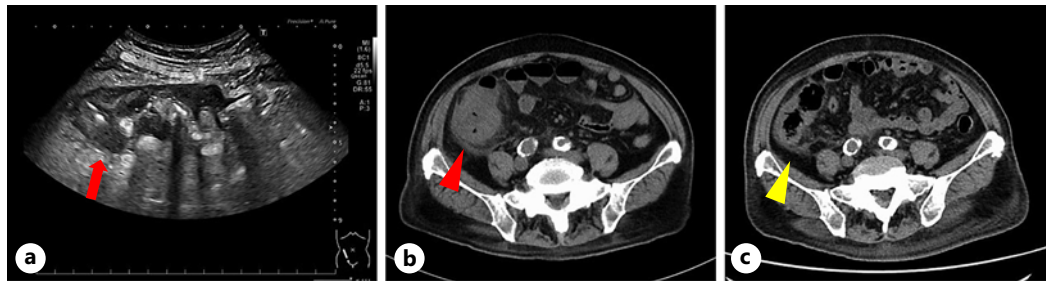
a Ultrasound showing bowel wall thickening of the ascending colon (arrow). b Abdominal computed tomography (CT) showing bowel wall thickening and increased CT value of panniculitis of the ascending colon (red arrowhead). c Follow-up CT after 2 weeks showing improvement in bowel wall thickening and an increased CT value of panniculitis of the ascending colon (yellow arrowhead).
